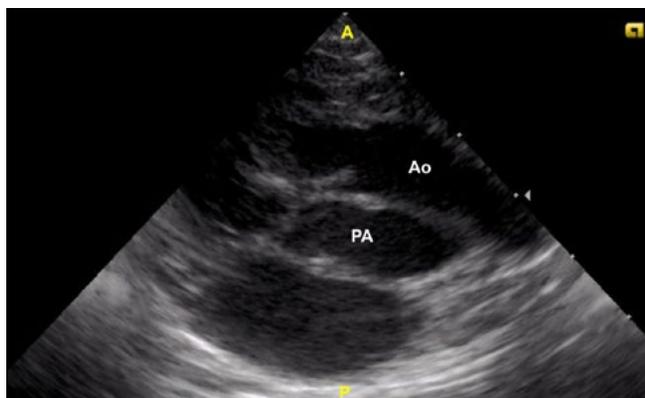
Postnatal transthoracic echocardiogram of the parasternal long axis with the great vessels running in parallel. Ao – aorta; PA – pulmonary artery; A – anterior; P – posterior
